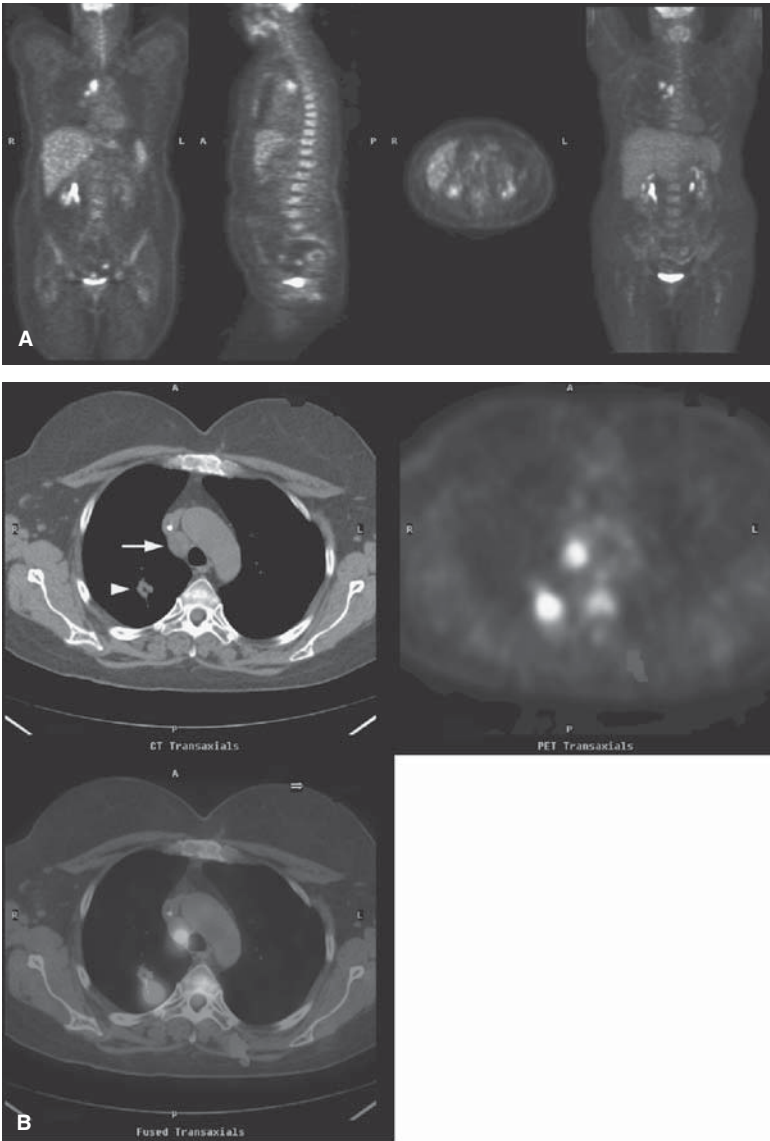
Right upper lobe NSCLC with ipsilateral metastatic adenopathy and a benign left adrenal adenoma. (A) FDG-PET whole-body scan demonstrating a right hilar malignancy with ipsilateral metastatic adenopathy. No evidence of distant disease is seen. (B) Axial FDG-PET/CT image through the right upper lobe lesion (white arrowhead) and the right paratracheal nodal metastasis (white arrow). Also notice the slight image misregistration.
